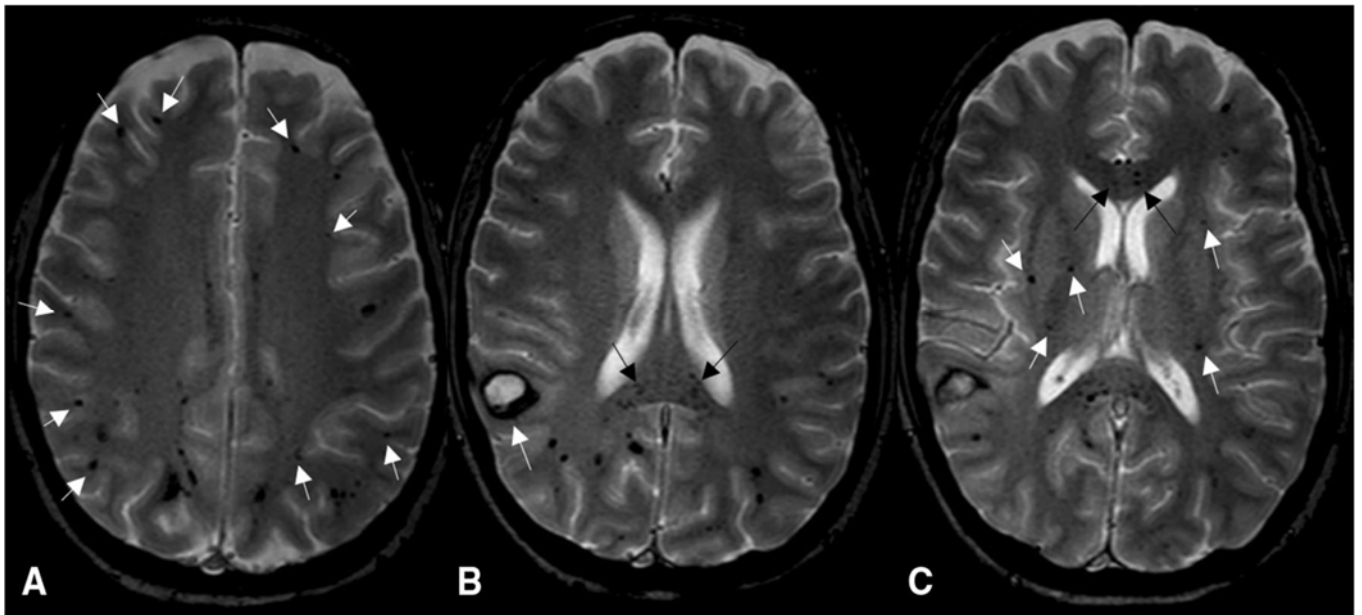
Gradient echo magnetic resonance images, left to right correspond to axial slices from cranial to caudal through the brain. Microbleeds are shown as multiple hypo-intense foci of hemosiderin deposition bilaterally. These are most abundant in the juxtacortical white matter (white arrows in a) and in the corpus callosum (black arrows in b and c). There are also several lesions in the deep white matter (white arrows in c). A larger, symptomatic hemorrhage is also visible
